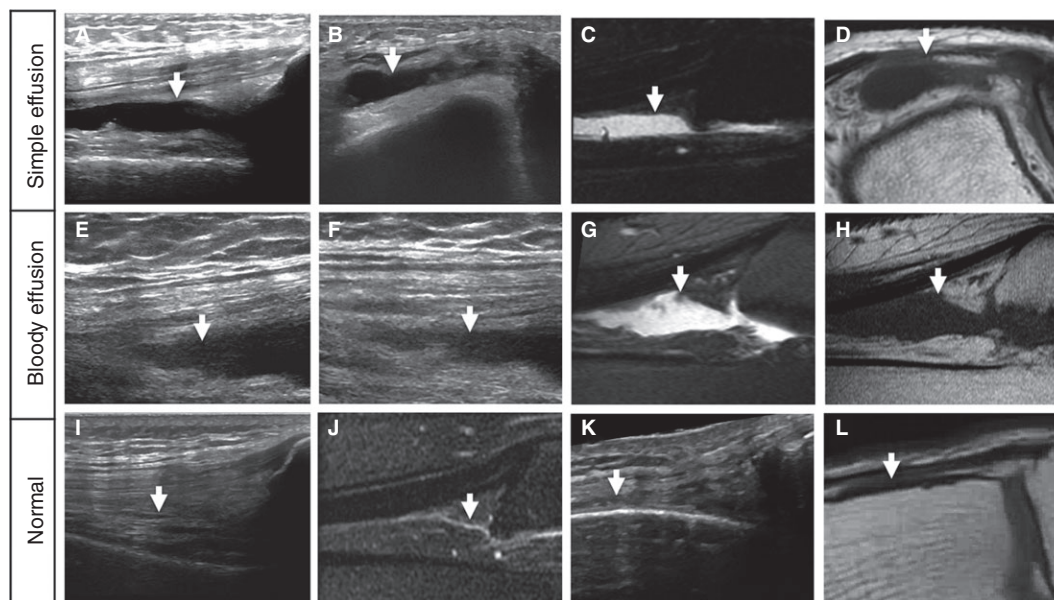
Timely correlated MSKUS and MR images in two hemophilic patients with simple and bloody effusions in relation to normal anatomy. (A/B) A 70-year-old man with a simple effusion on MSKUS: longitudinal image through the suprapatellar recess and short axis image through the lateral recess show anechoic joint fluid (arrows) consistent with simple effusion, confirmed through joint aspiration. (E/F) A 57-year-old man with a bloody effusion on MSKUS: longitudinal images through the suprapatellar recess applying different degrees of real-time compression show joint fluid with echogenic reflectors (arrows), consistent with bloody effusion, confirmed through joint aspiration. (C/D and G/H) Corresponding MR images to A/B and E/F. Sagittal T2-weighted fat-suppressed and axial/sagittal T1-weighted images confirm joint effusions (arrows) in both cases, but are unable to distinguish between simple and bloody effusions. Simple fluid in C and D appears qualitatively similar to the bloody fluid in G and H. I/K and J/L represent normal sonoanatomy and MR anatomy of the suprapatellar and lateral recess, respectively. The normal recesses, which are entirely collapsed, are annotated with arrows. MSKUS, musculoskeletal ultrasound; MR, magnetic resonance.
